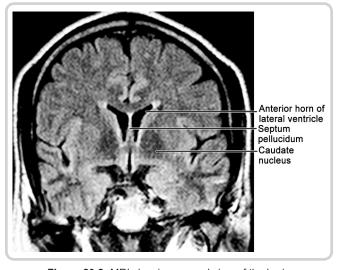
MRI showing coronal view of the brain (Courtesy: Dr. H. D. Deshmukh, Professor & Head, Department of Radiology, Seth GS Medical College & KEM Hospital, Mumbai)
